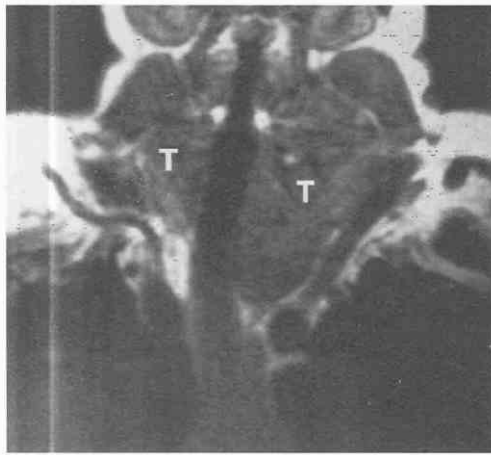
Mediastinal goiter. Coronal MR image shows mediastinal thyroid tissue (T) on both sides of trachea, which is deviated to the right at the thoracic inlet.
